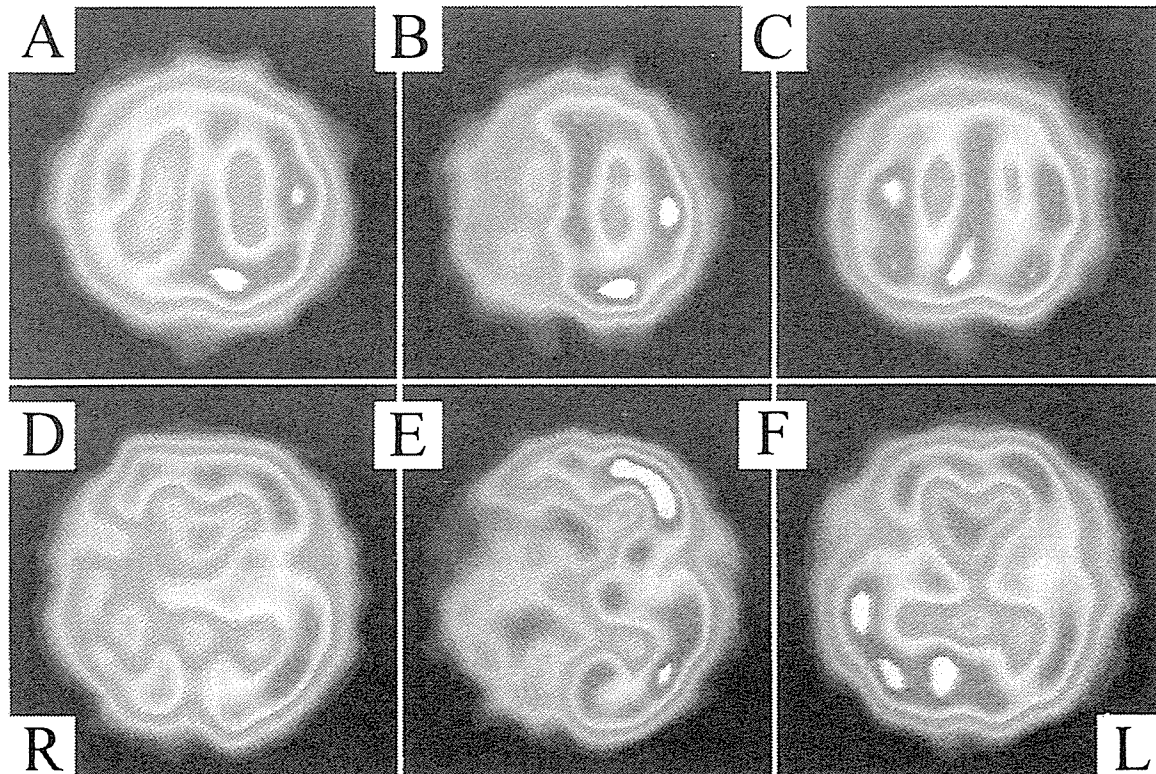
Case 2. A and D: Preoperative ^{123}I -IMP SPECT scans showing severe hypoperfusion in the right hemisphere including the basal ganglia. B and E: Preoperative ^{123}I -IMP SPECT scans obtained after acetazolamide infusion, revealing a marked decrease in vascular reserve in the right hemisphere including the basal ganglia. C and F: Postoperative ^{123}I -IMP SPECT scans demonstrating improved CBF in the right hemisphere including the basal ganglia.
